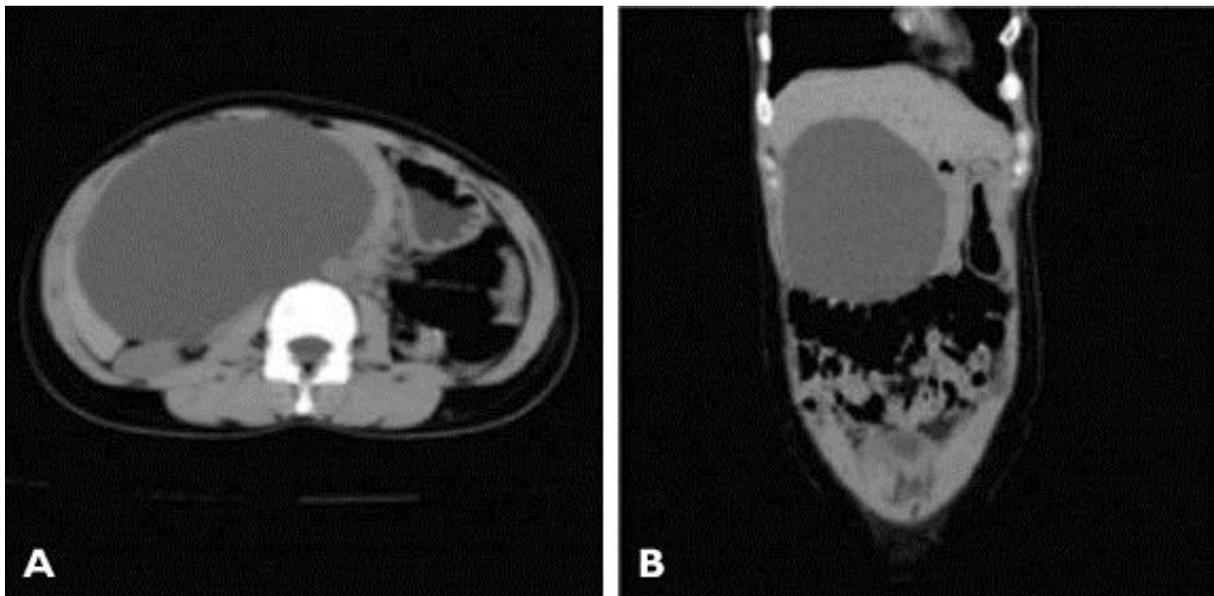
CT abdomen screening showed hypo dense homogenous cystic lesion of near water attenuation with subtle wall calcification.
